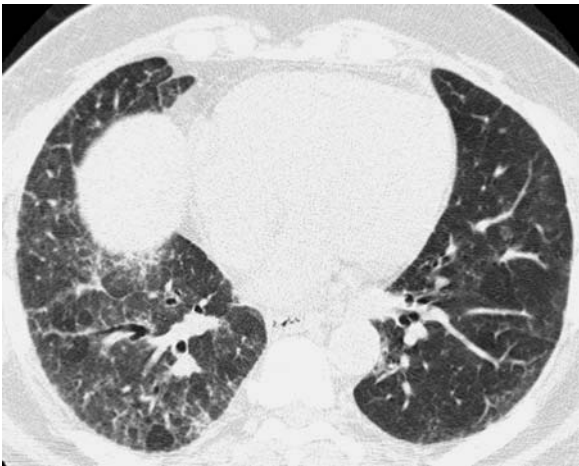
Thin-section computed tomography through the mid-lungs in a patient with chronic beryllium disease shows marked airway wall thickening and mild, predominantly peribronchovascular, ground glass abnormality
